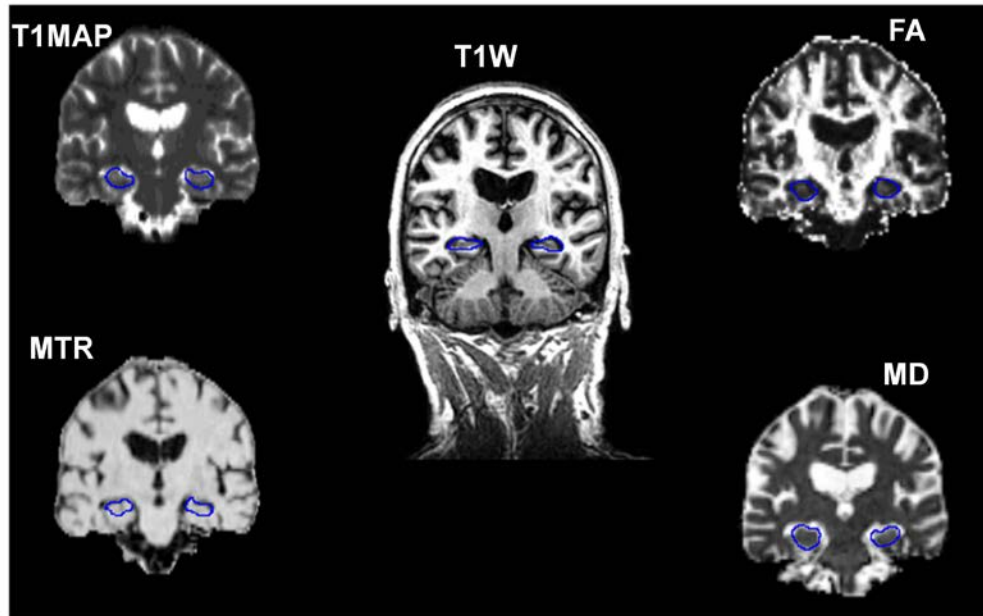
Typical images showing the quantitative MR images and the T1-weighted images with the outlines of the left and right hippocampi. T1MAP= T1 relaxation times, MTR = magnetization transfer ratio, MD = mean diffusivity and FA = fractional anisotropy.
